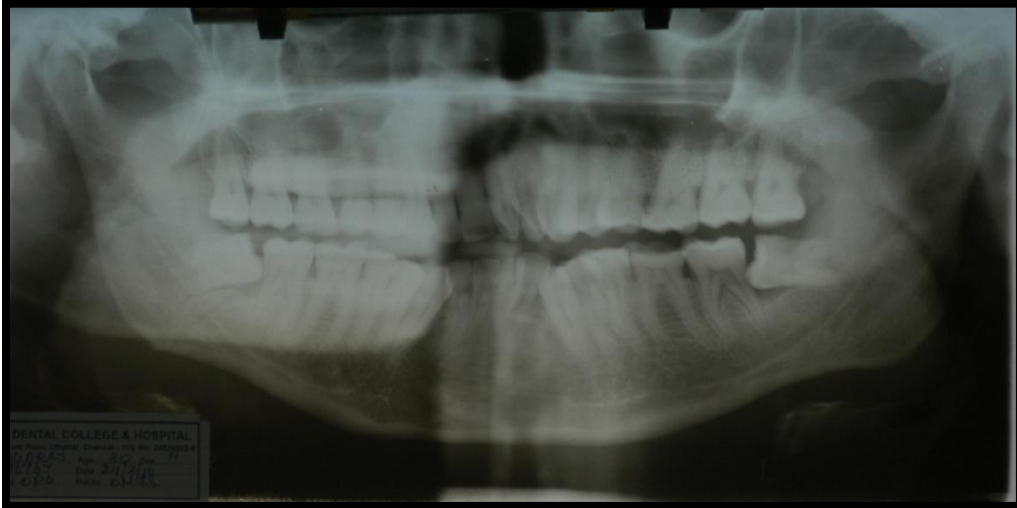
PRE OP ORTHOPANTOMOGRAM
